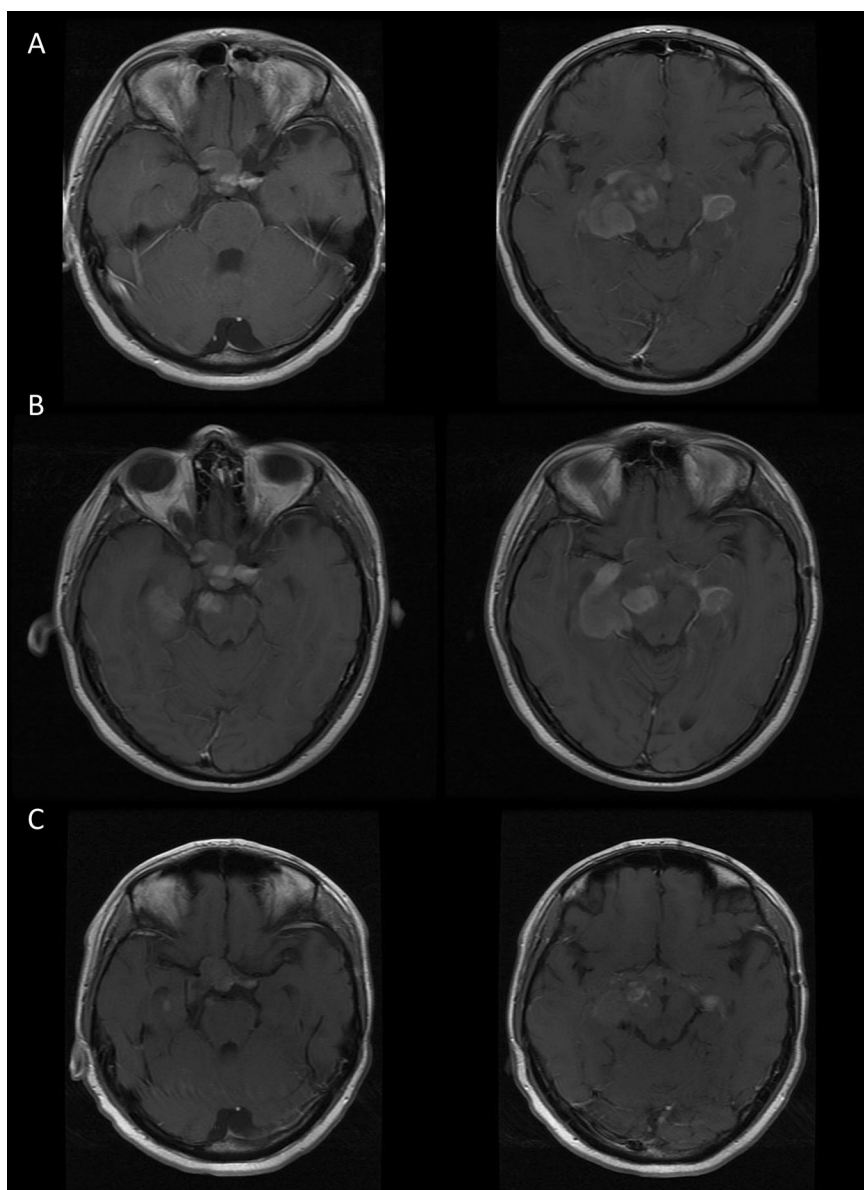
Tumor control following bevacizumab. A, Contrast enhancing MRI axial slices from a patient with an optic tract glioma previously treated with surgical debulking, carboplatin, vincristine, etoposide, vinblastine with progression noted at next scan 3 months later. B, Patient was started on bevacizumab with continued tumor stabilization over 4 years later (C).
